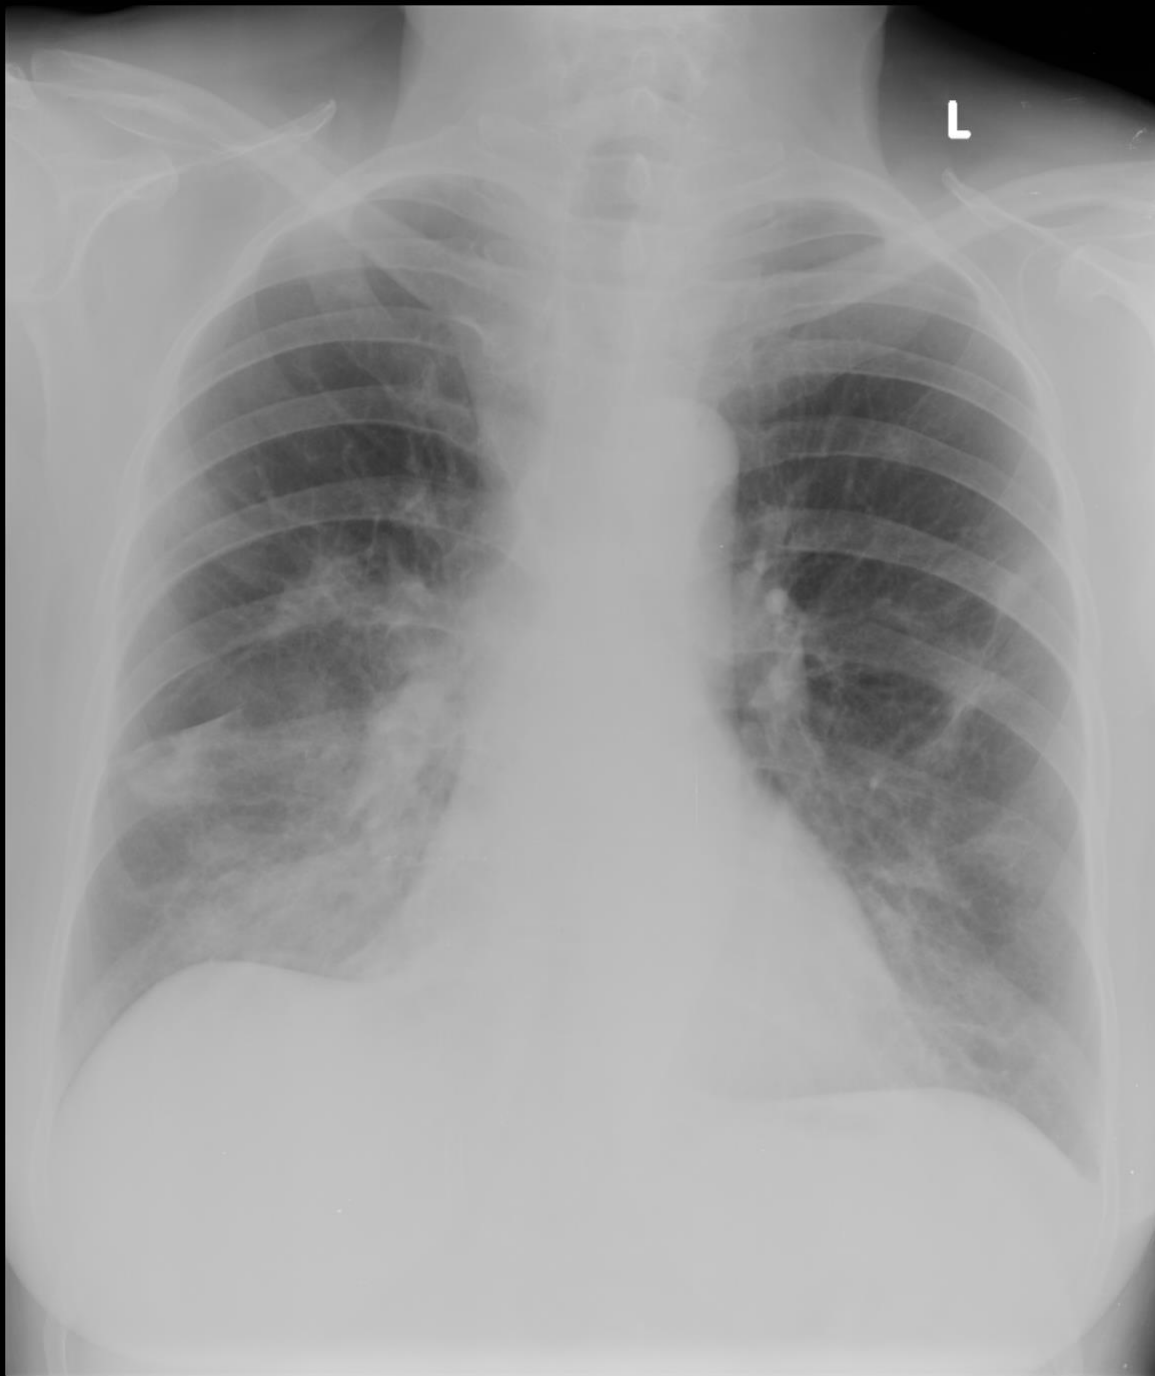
Chest radiograph done after clinical progression 20.03.2020.
